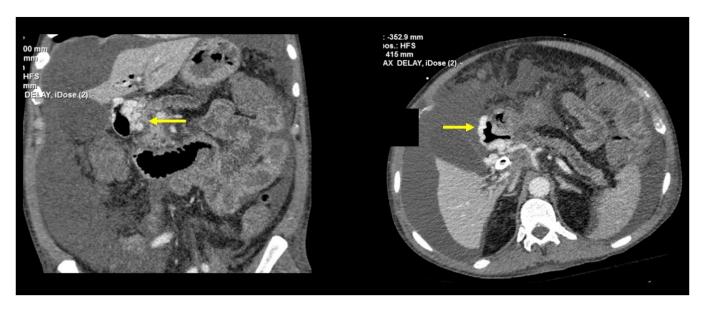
A contrast-enhanced CT scan showing the prior cavernous transformation of the portal vein that led to development of duodenal varices (*arrows*).
